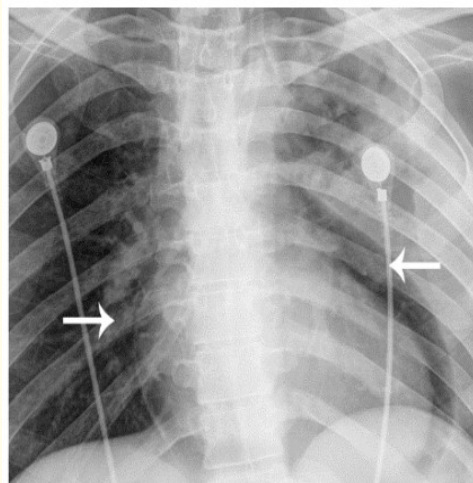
X-ray chest showing “halo sign” suggesting air in pericardial space (white arrows).
